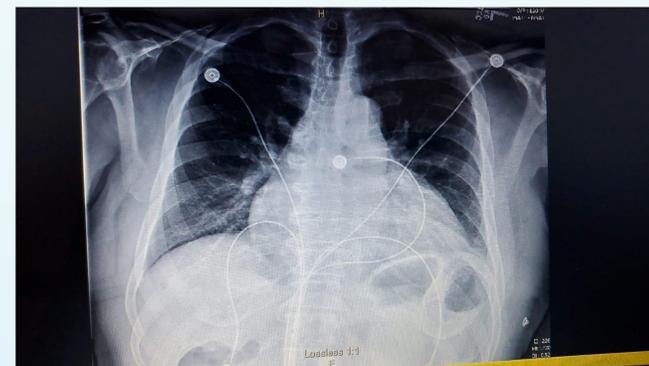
Chest X-ray showing an enlarged cardiac silhouette but no consolidation, infiltrates or masses
